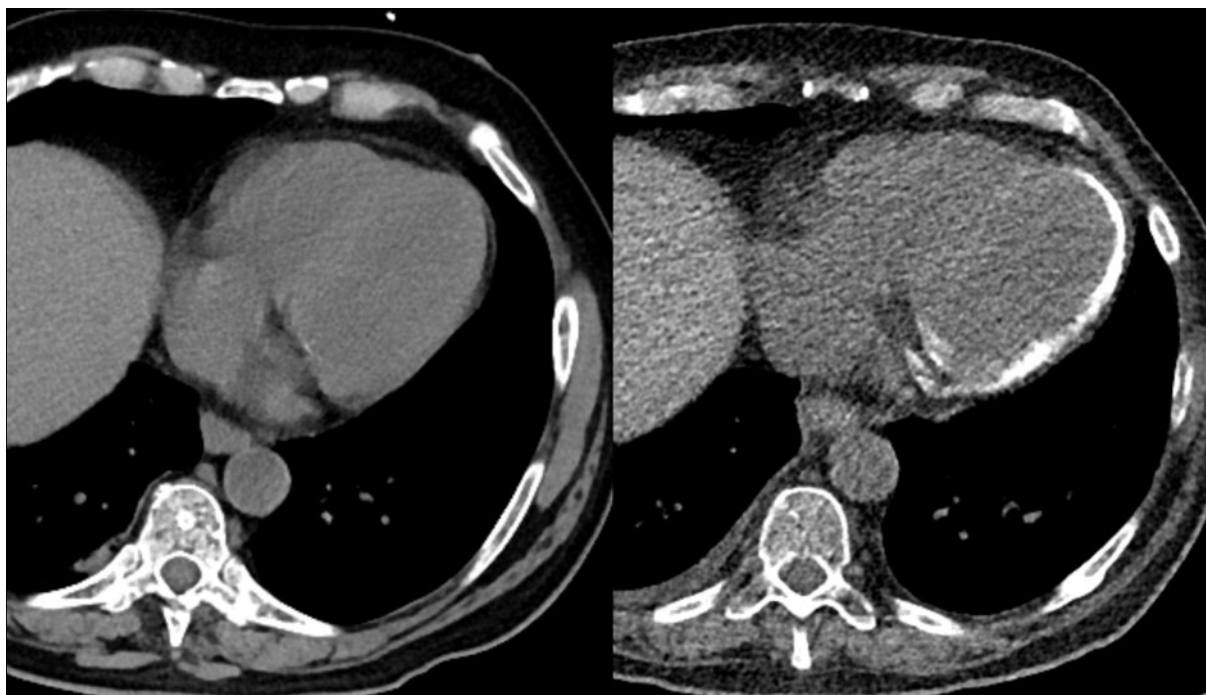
Non-contrast enhanced CT scans of the chest initially during onset of pneumogenic sepsis (right) and after 10 weeks (left) show rapid development of non-preexisting, extensive myocardial calcifications.
